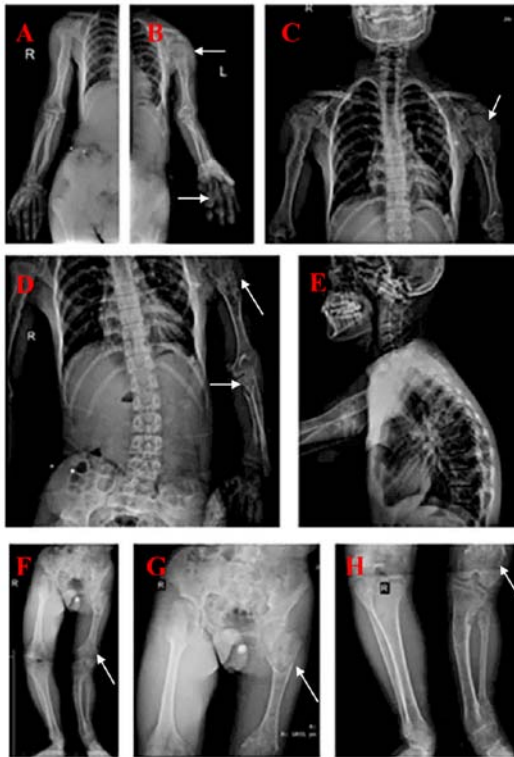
X-ray images of the lower limbs, upper limbs and shoulder blades demonstrate formation of multiple enchondroma. Developmental malformations of (A) R humerus, ulna and hand, (B) L hand, (C) humerus, (D) radius, (E) thoracic vertebrae, (F) L femoral condyle (G) trochanter of femur and tibia and (H) fibula. R, right; L, left; The white arrows are pointing to tumors.
